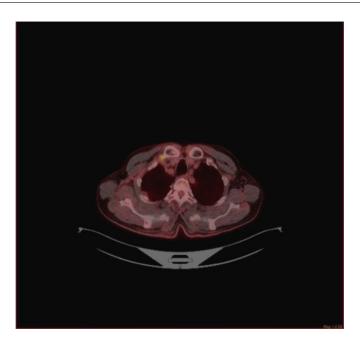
Fusion axial reformatted images of a PET\CT Scan show nodular radiotracer uptake in the region corresponding to the RIGHT costoclavicular ligament.
